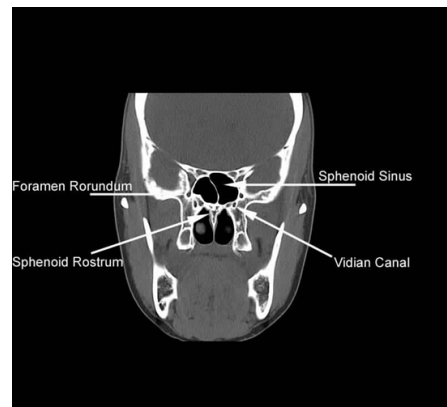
A CT axial image showing anatomy of sinus
